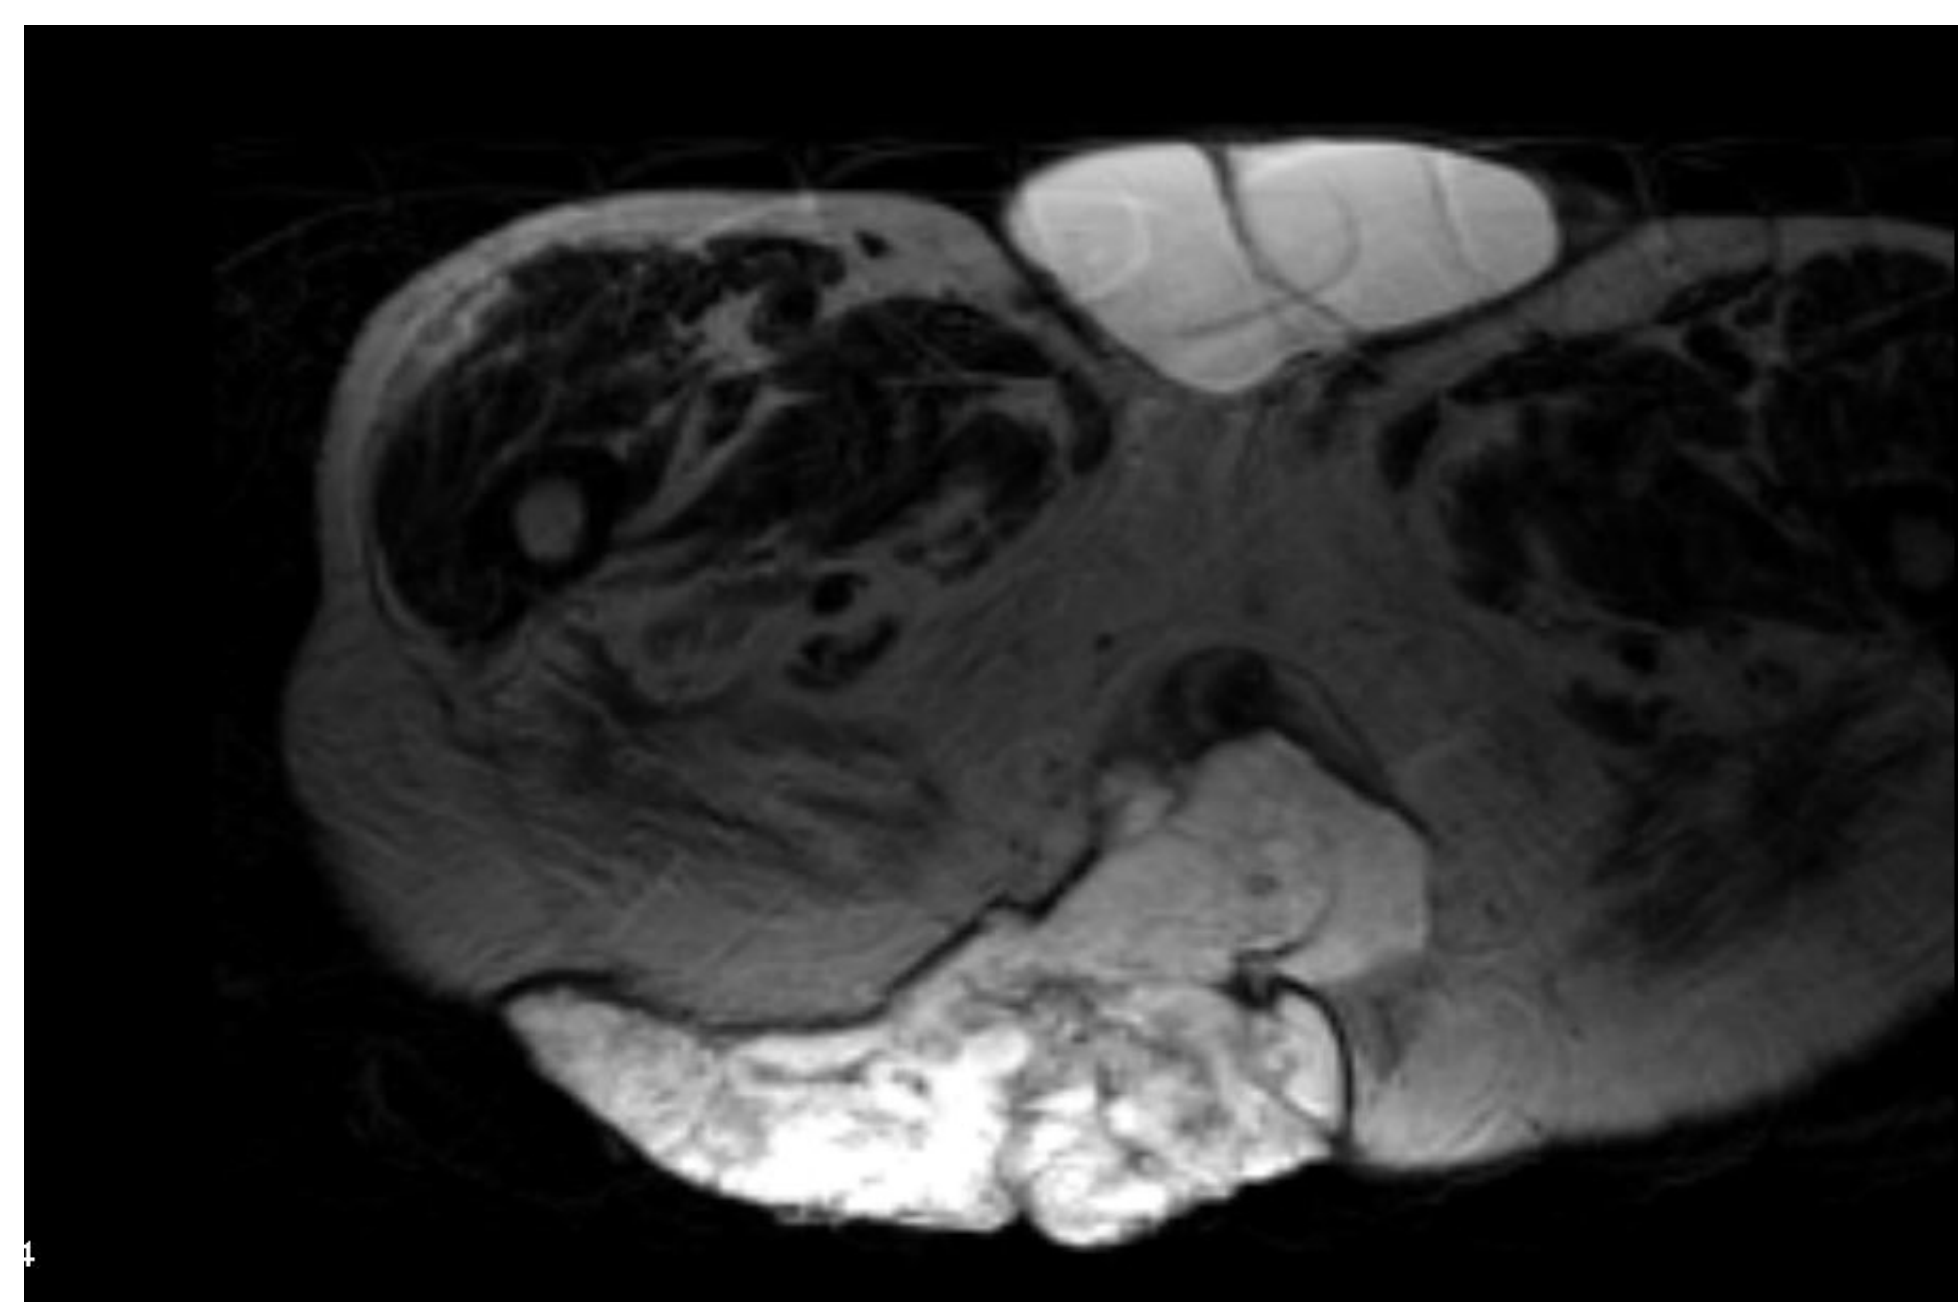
MRI Pelvis w/ & w/out contrast
